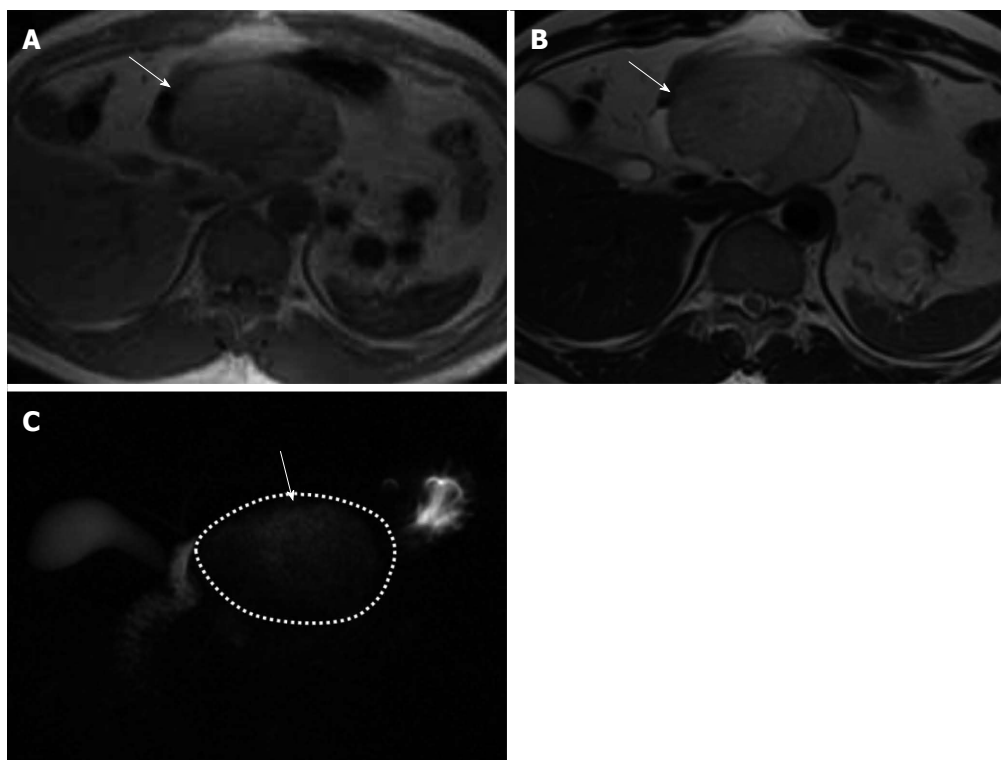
Findings of patient #1. A: Findings of T1-weighted imaging on magnetic resonance imaging (MRI). T1-weighted imaging of patient showed a higher intensity than free water (arrow); B: Findings of T2-weighted imaging on MRI. T2-weighted imaging of patient showed a lower intensity than free water (arrow); C: Findings of magnetic resonance cholangiopancreatography (MRCP). MRCP of patient showed a lower intensity than free water (arrow).
